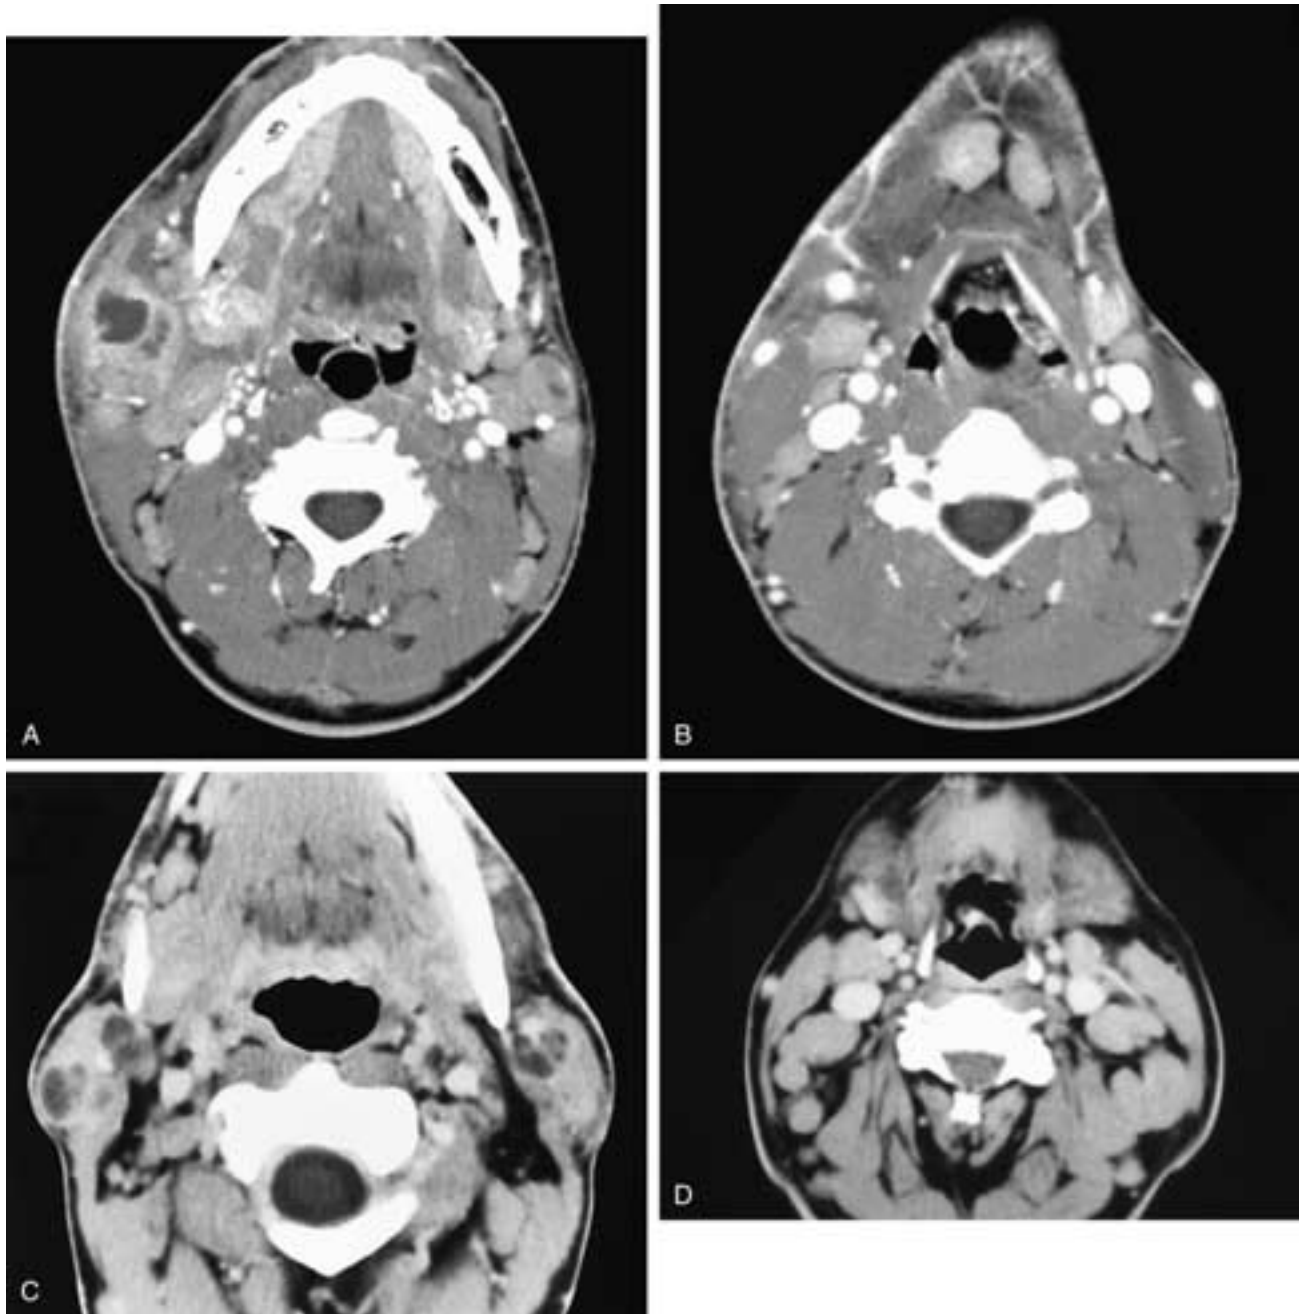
Axial CT scans (A, B) show cysts in both parotid glands with bilateral level I and II lymphadenopathy. This patient was HIV positive and had lymphoepithelial cysts. Axial contrast-enhanced CT scans on another patient show multiple cystic masses in both parotid glands (C) and diffuse cervical adenopathy (D). This patient was HIV positive and had lymphoepithelial cysts.
